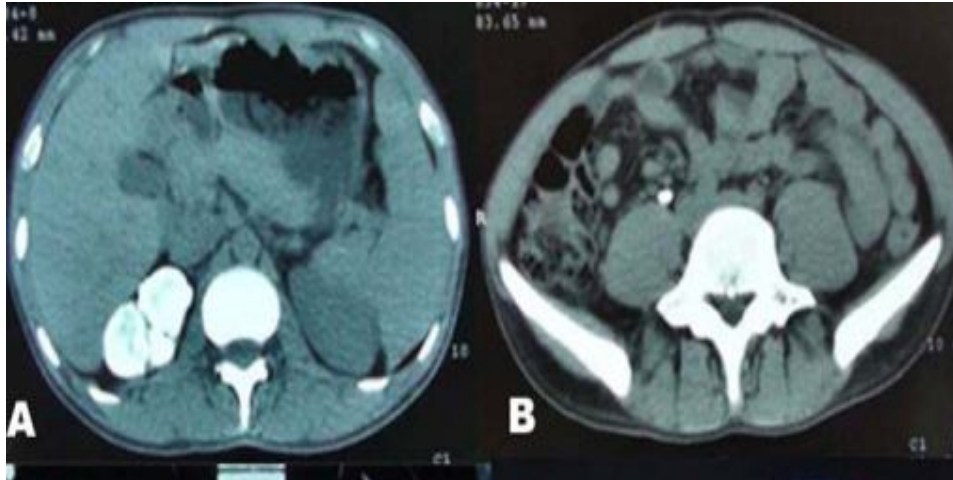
(A) Axial non-contrast CT image showing renal calcification
